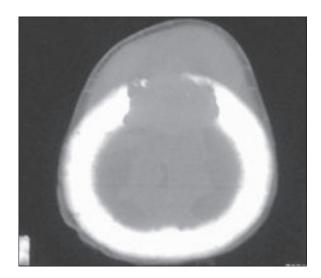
Pre operative CT scan of head showing erosion of skull bone with tumor extension.
